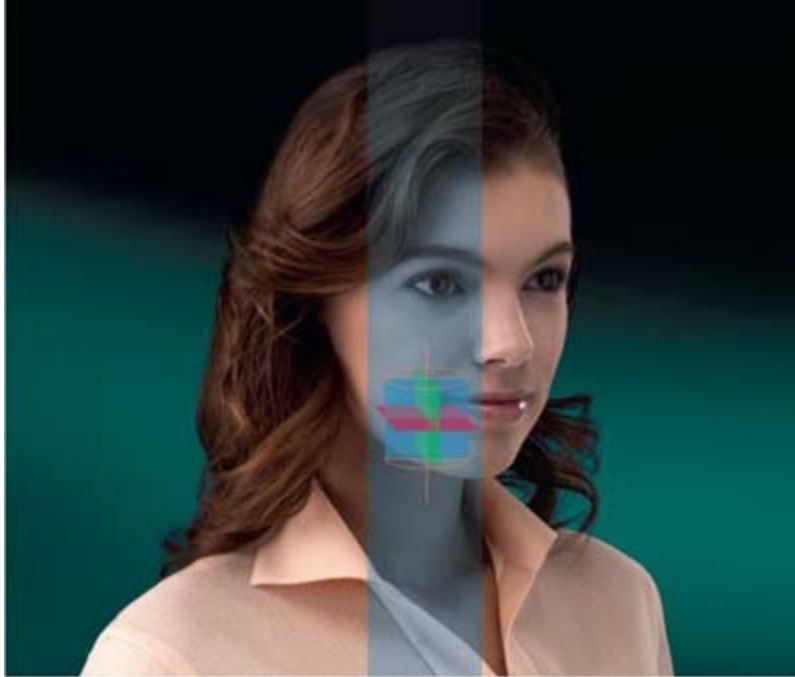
Cone-beam volumetric tomography has the ability to capture, store, and present radiographic images in various horizontal and vertical planes.
